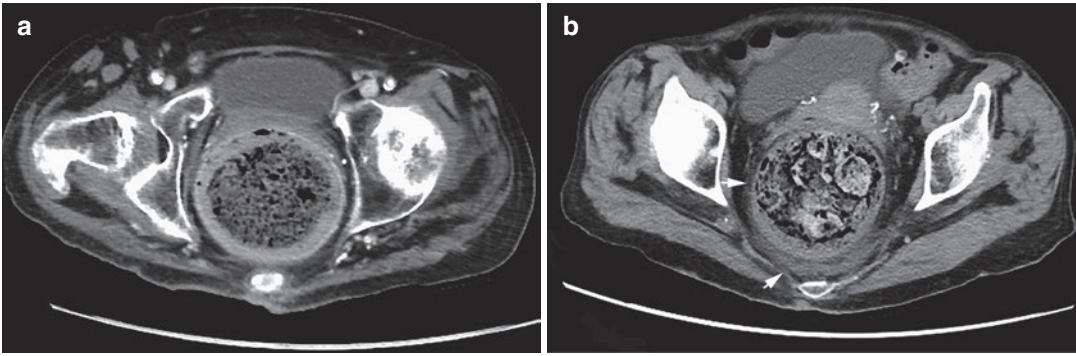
A 78-year-old female with chronic constipation presents with abdominal pain and was found to have stercoral colitis. (a) Axial CT following intravenous contrast
